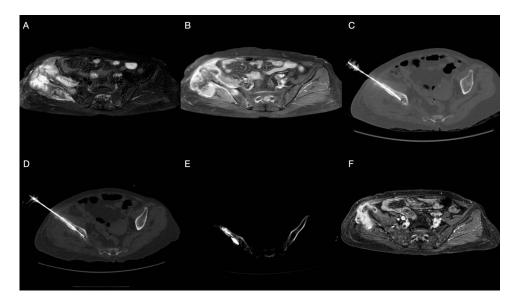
Changes of lesions before and after surgery in a patient with lung cancer and right iliac bone metastasis. (A and B) MRI shows right iliac bone metastasis; (C) Bone puncture needle reaches the target lesion area; (D) Microwave ablation needle performs ablation treatment in the target lesion; (E) Bone puncture needle injects bone cement into the lesion; (F) Follow-up MRI at 3 months postoperatively shows significant weakening of the enhancement in the target lesion area.
